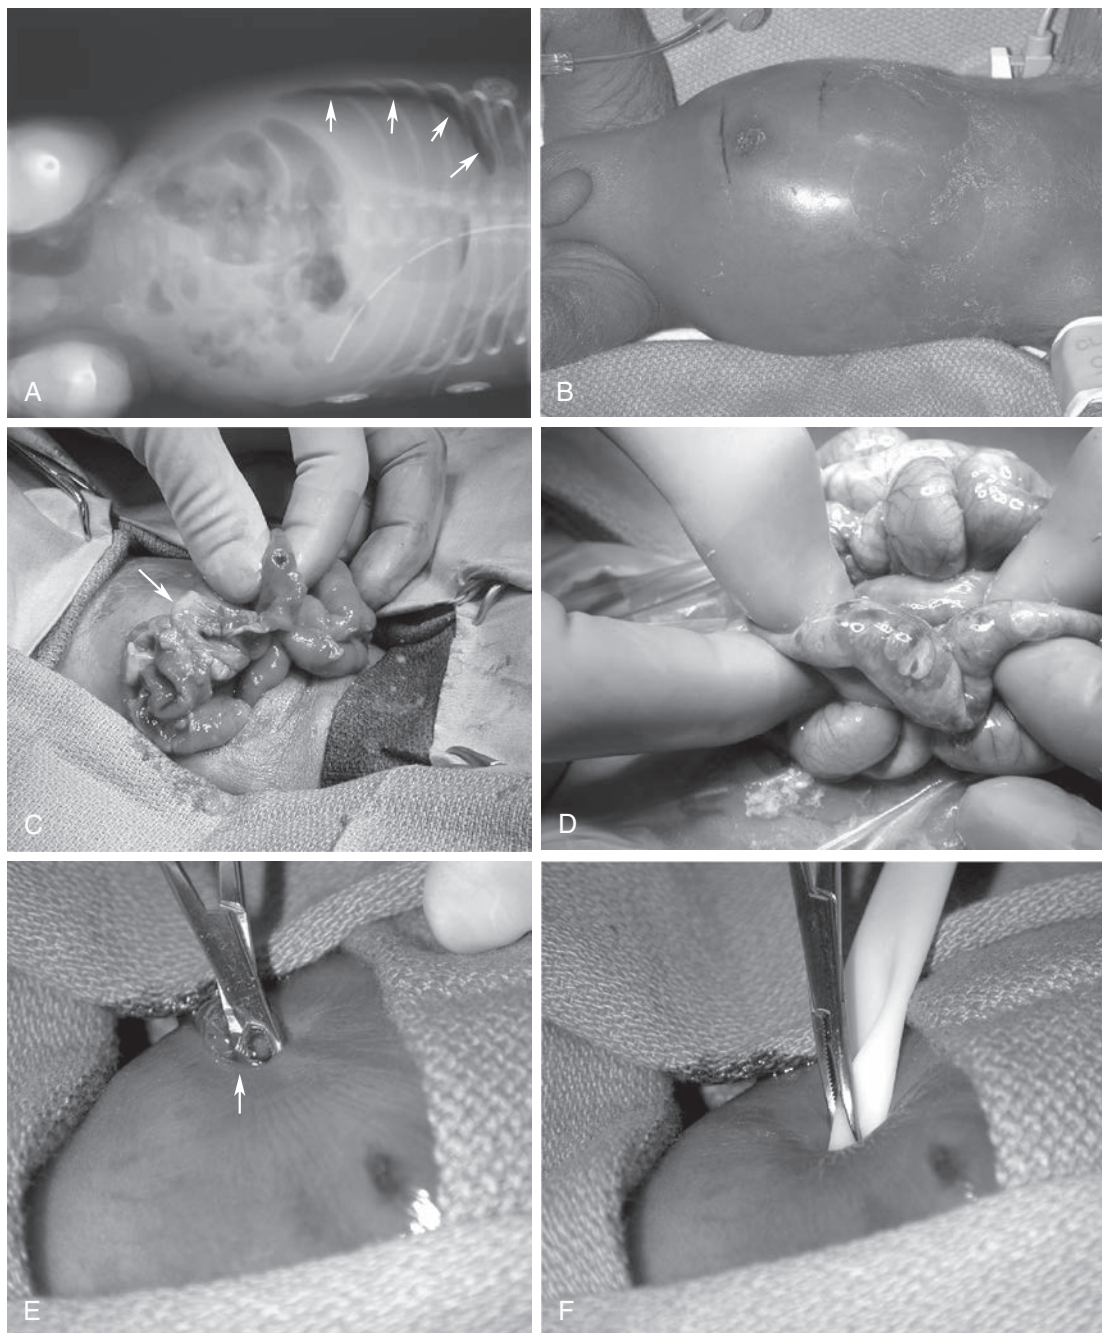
Several different examples of necrotizing enterocolitis (NEC) in ELBW infants. A, B, Pneumoperitoneum on abdominal radiograph (arrows in A); B, Same baby. Note abdominal distention and discoloration. C, Findings of NEC at laparotomy: perforation is shown between surgeon's fingers. Arrow shows segment of gangrenous bowel. Bowel toward surgeon's middle finger is normal. D, Example of pneumatosis intestinalis; this baby had pan-intestinal necrosis. E, F, Placement of peritoneal drain in the neonatal intensive care unit (NICU). Arrow shows release of pneumoperitoneum (bubbles).
